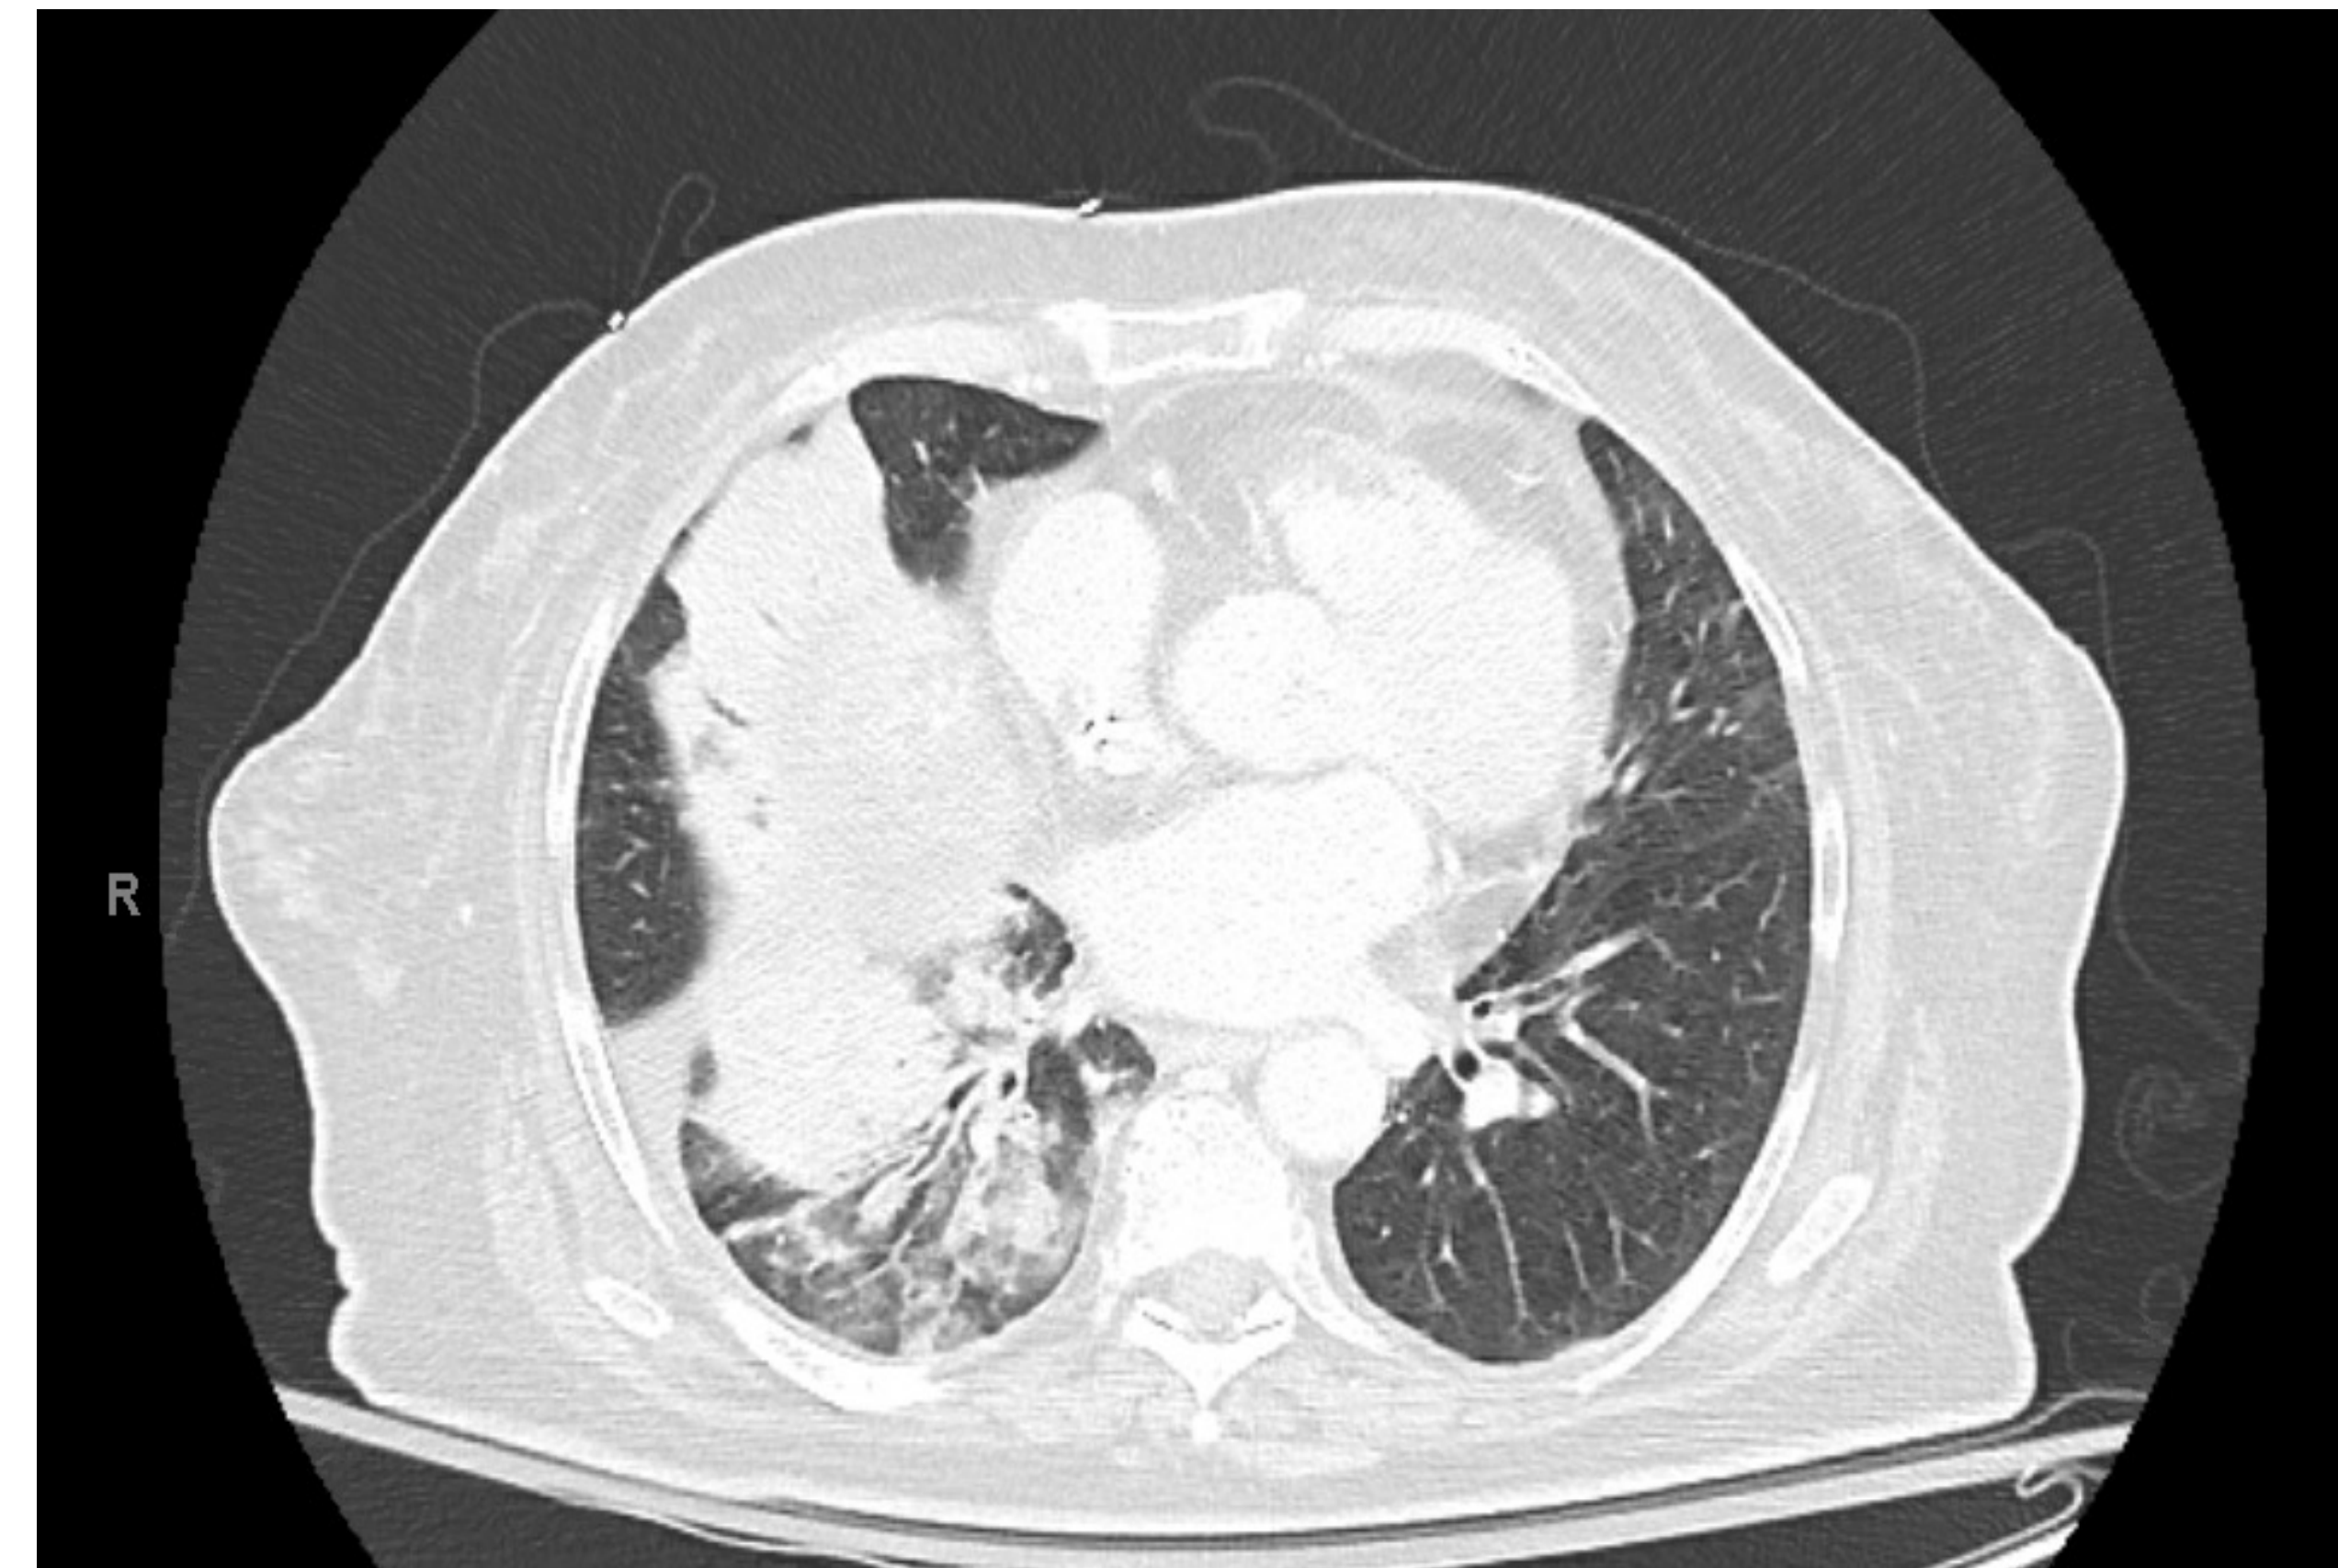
CT Thorax with RLL opacities
